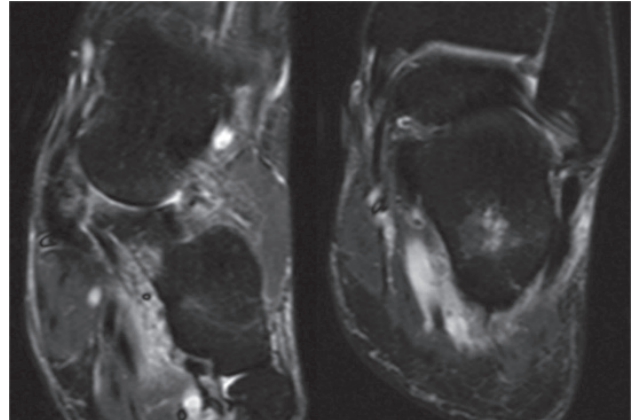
Coronal STIR T2-w MR images.
